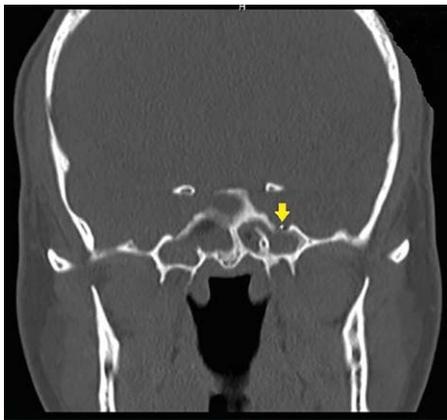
The 3.6 mm defect in the sphenoid sinus lateral recess is shown in the coronal section PNS CT of patient 2.
